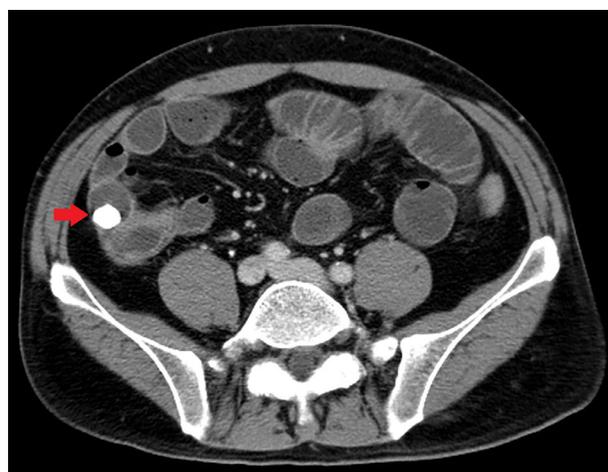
Contrast-enhanced abdominal computed tomography revealed a radio-opaque density with a diameter of about 1.4 cm in the distal ileum.
